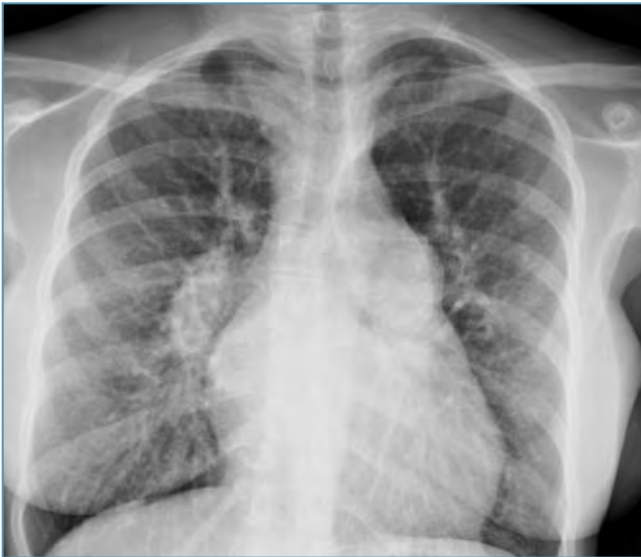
Chest radiography demonstrating mild cardiomegaly, large main pulmonary artery segment and peripheral pruning.
